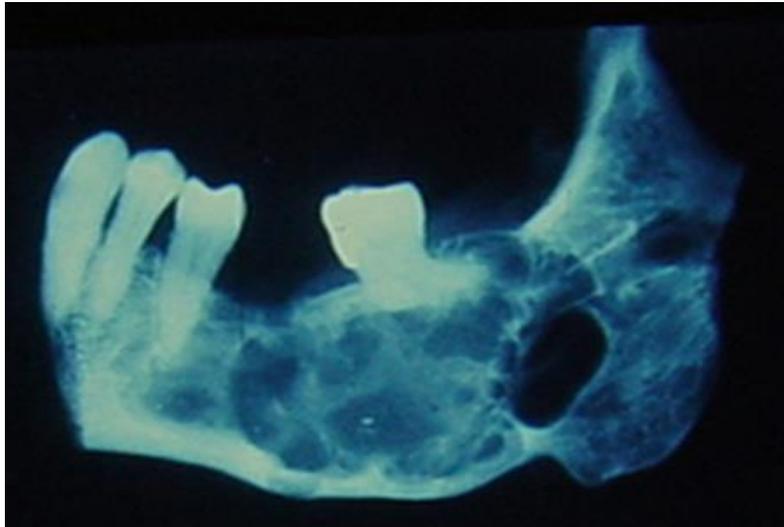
g.- X-ray showing the destruction of the lower jaw with resorption of the dental root.
